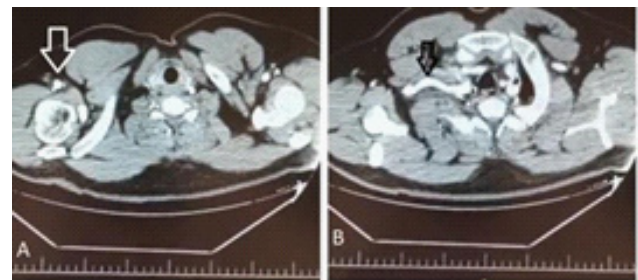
Contrast-enhanced computed tomography (CT). A, Right axillary artery (White arrow). B, right subclavian artery (Black arrow)
